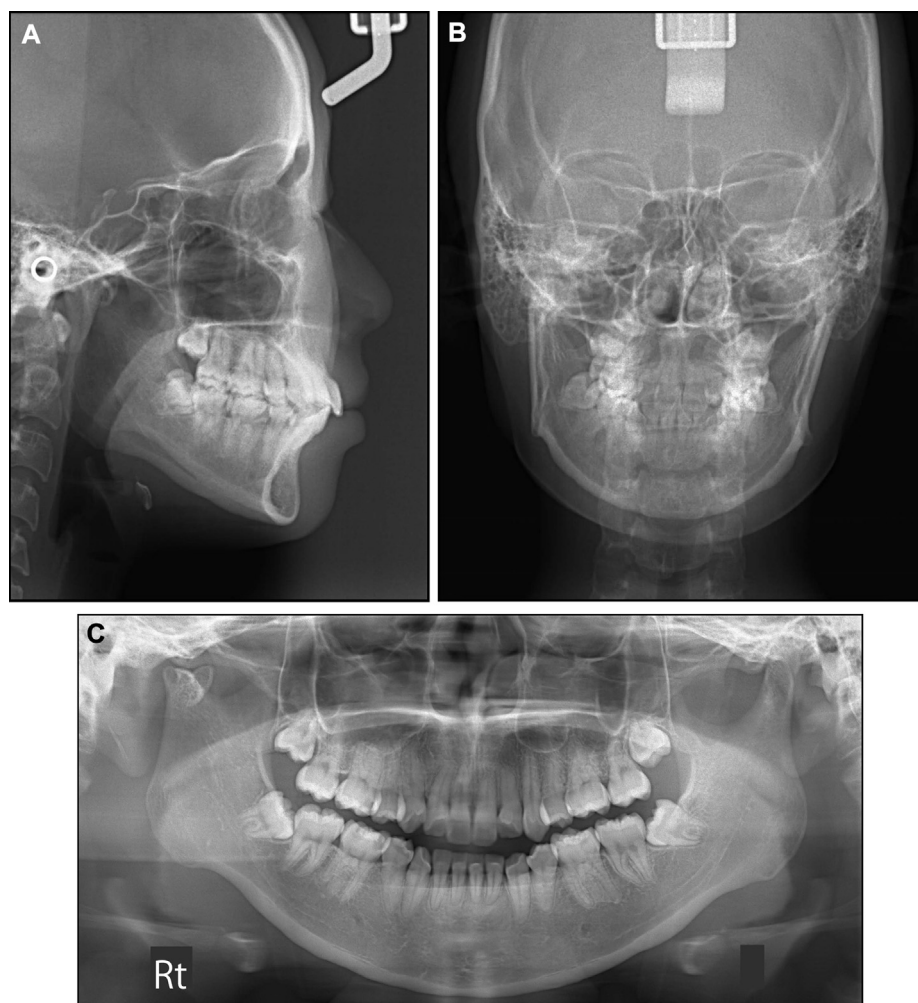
Thirty-month posttreatment radiographs: A, lateral cephalogram; B, posteroanterior cephalogram; C, panoramic radiograph.
